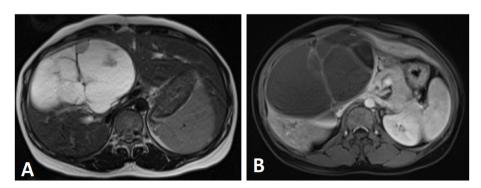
Magnetic resonant imaging of the liver shows a multilocular cystic. (A) T2-weighted image shows a multiple septation cystic lesion. (B) T1 weighted image shows multiple thick internal separations with enhancement, there was no mural nodules.
